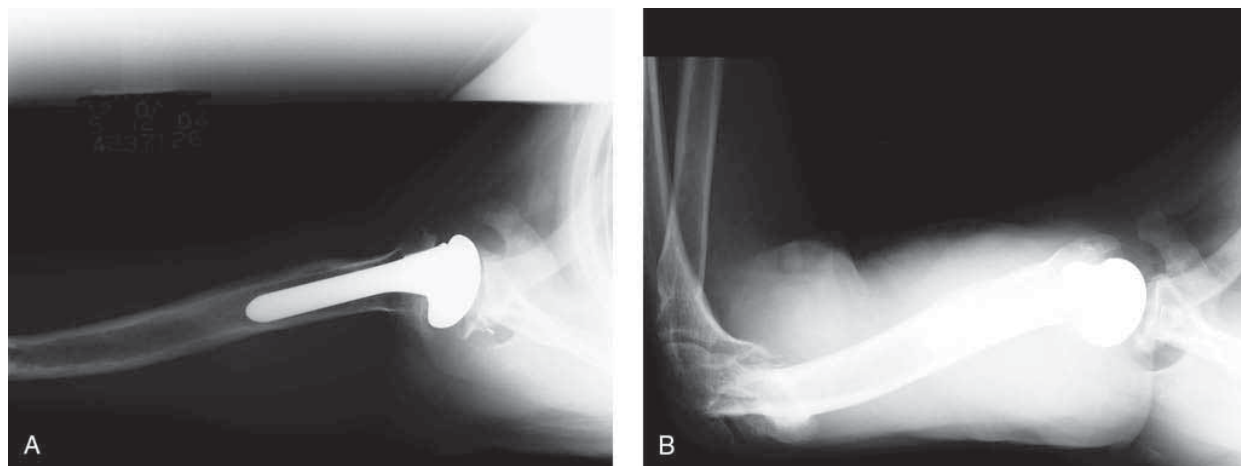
Radiographs of the shoulder of a 47-year-old man who had increasing pain and loss of function 2 years after total shoulder arthroplasty for instability-associated arthritis. A, Axillary radiograph reveals glenoid component loosening. B, Axillary radiograph shows revision placement of a new glenoid component.
